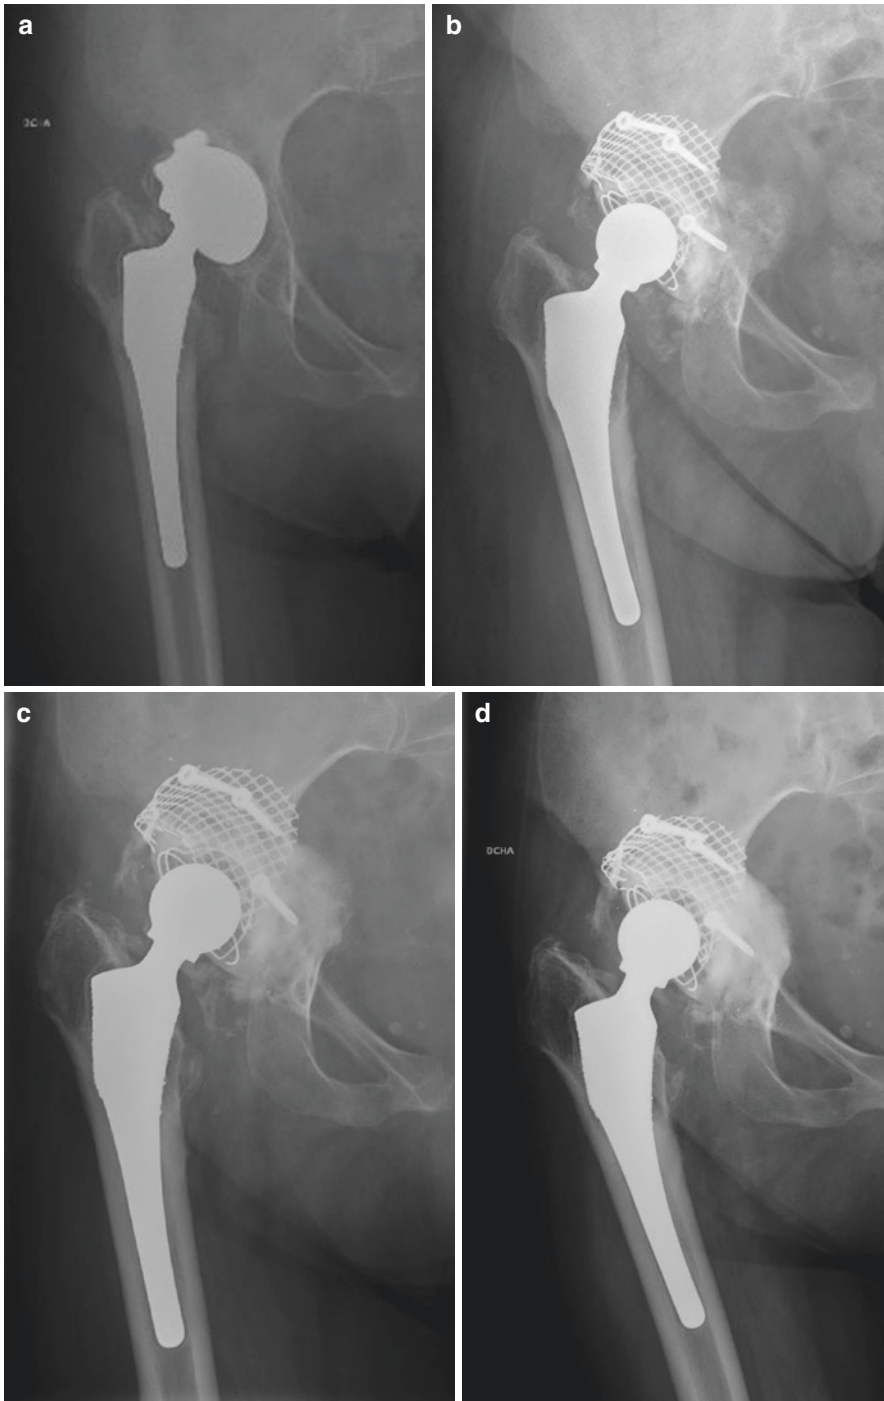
(a) Anteroposterior radiograph of a hip shows a cementless loosened cup. (b) Postoperative radiograph 3 months after impacting allograft bone grafting with a cemented cup used in revision surgery. (c) Radiograph 6 months post-surgery. (d) Radiograph 1 year post-surgery. (e) Radiograph at 5 years post surgery. Observe the progression of allograft remodelling
